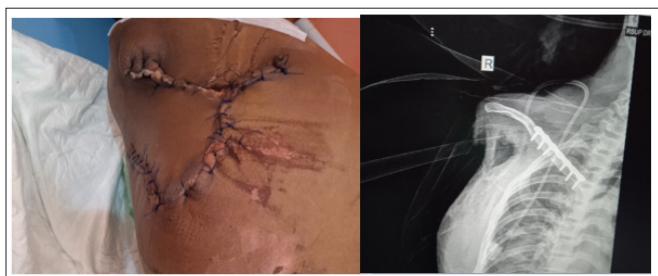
Visual Assessment Post-ORIF Procedure: Surgical Wound Site Post-ORIF Procedure and Chest X-ray Post-ORIF Procedure
